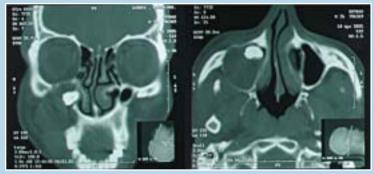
CT Scan showing hypodense region in the posterior maxilla
